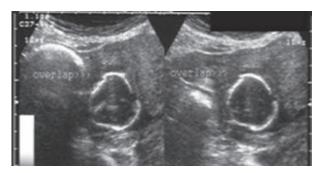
Sonographic findings of a case of IUFD
